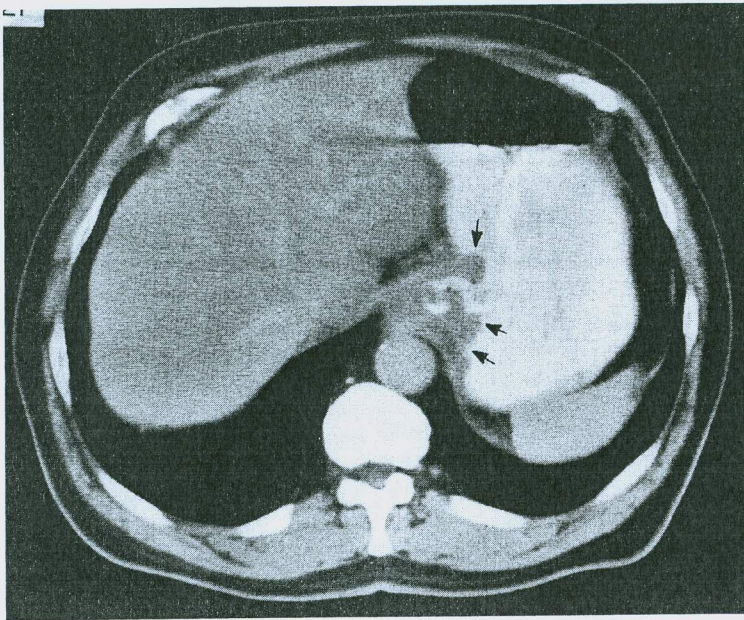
CT examination of the abdomen. Arrows denote tumor mass, a gastric adenocarcinoma of the cardia. (Courtesy of Dr. Howard Ansel.)
